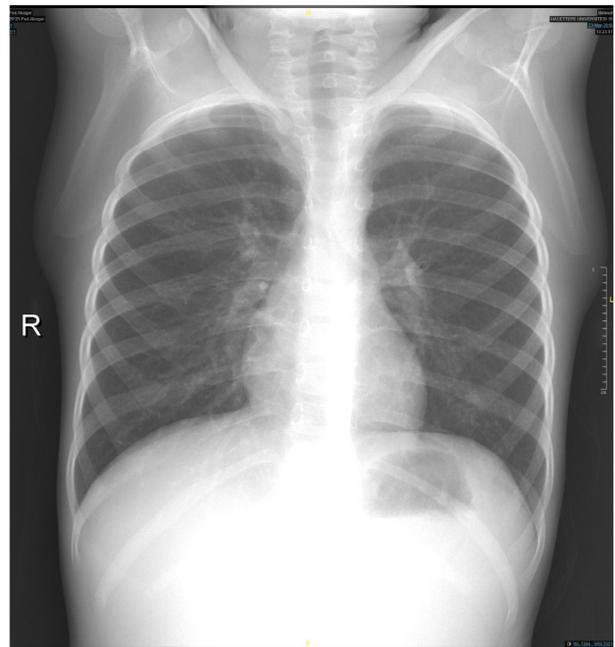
Chest X-Ray on diagnosis of asthma
